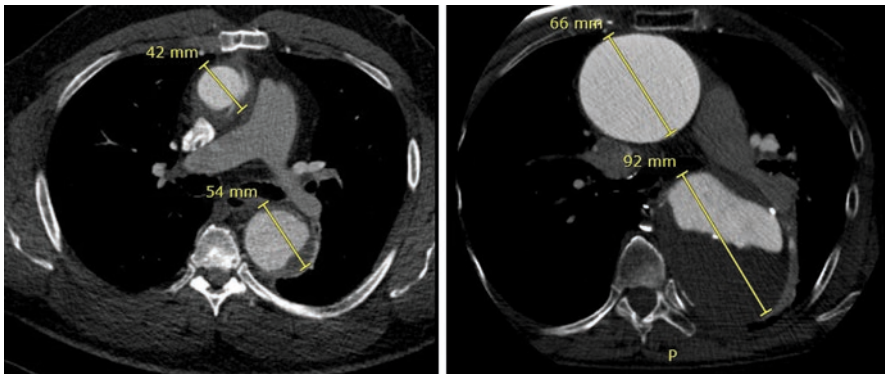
Serial axial contrast CT scan demonstrating enlarging ascending and proximal descending thoracic aortic aneurysms
